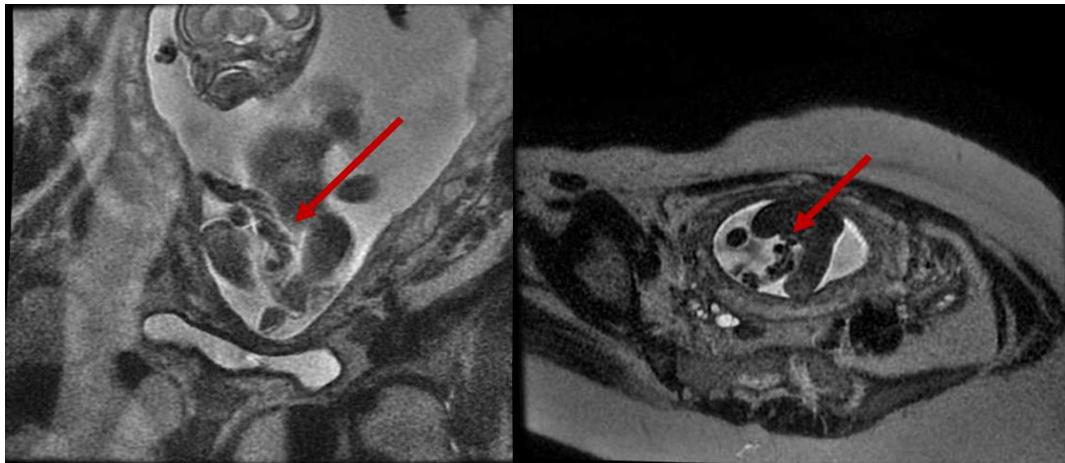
Coronal MRI image showing bulging mass with low cord insertion
